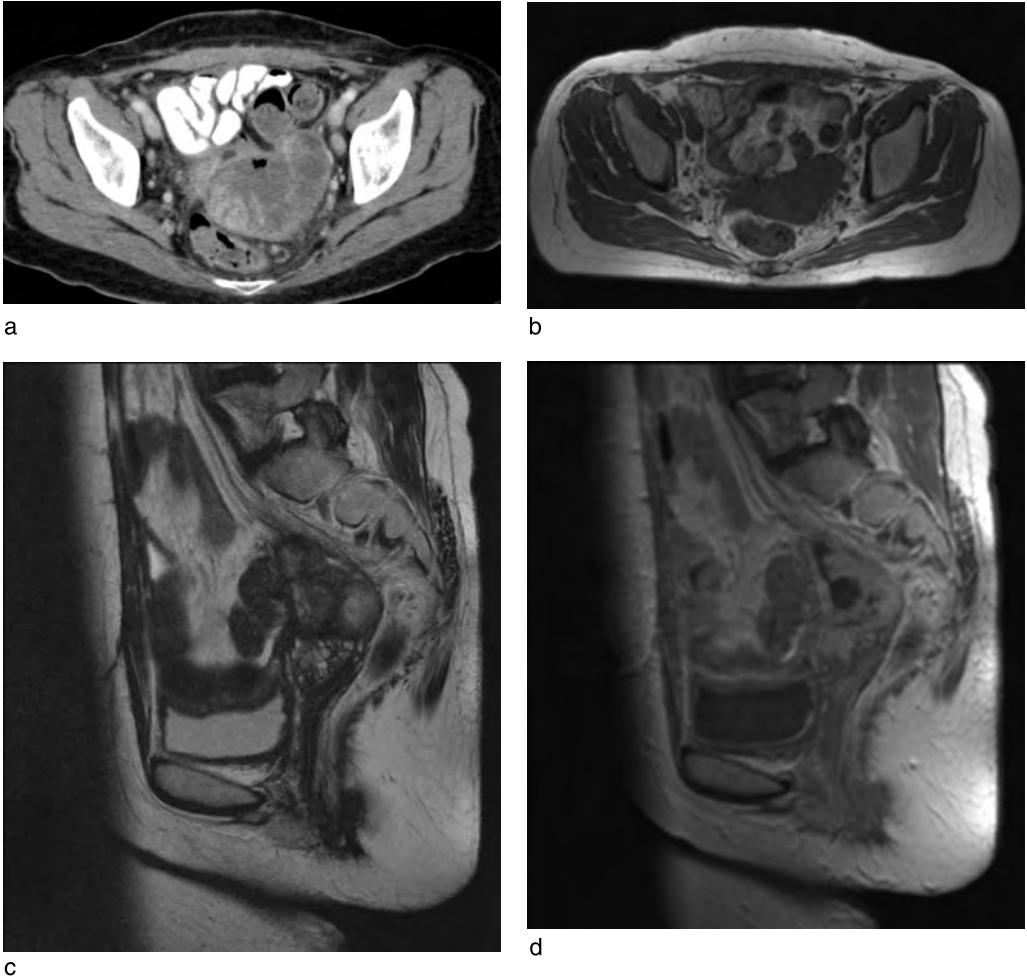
Baseline post-surgery pre-chemotherapy contrast enhanced CT showing (a) a complex pelvic mass ? haematoma ? abscess ? tumour and 3 weeks later into chemotherapy the MR images (b) axial T1-weighted showing no products of haemorrhage, (c) sagittal T2-weighted and (d) sagittal gadolinium-enhanced T1-weighted MR imaging showing a tumour deposit above a congested vagina.
